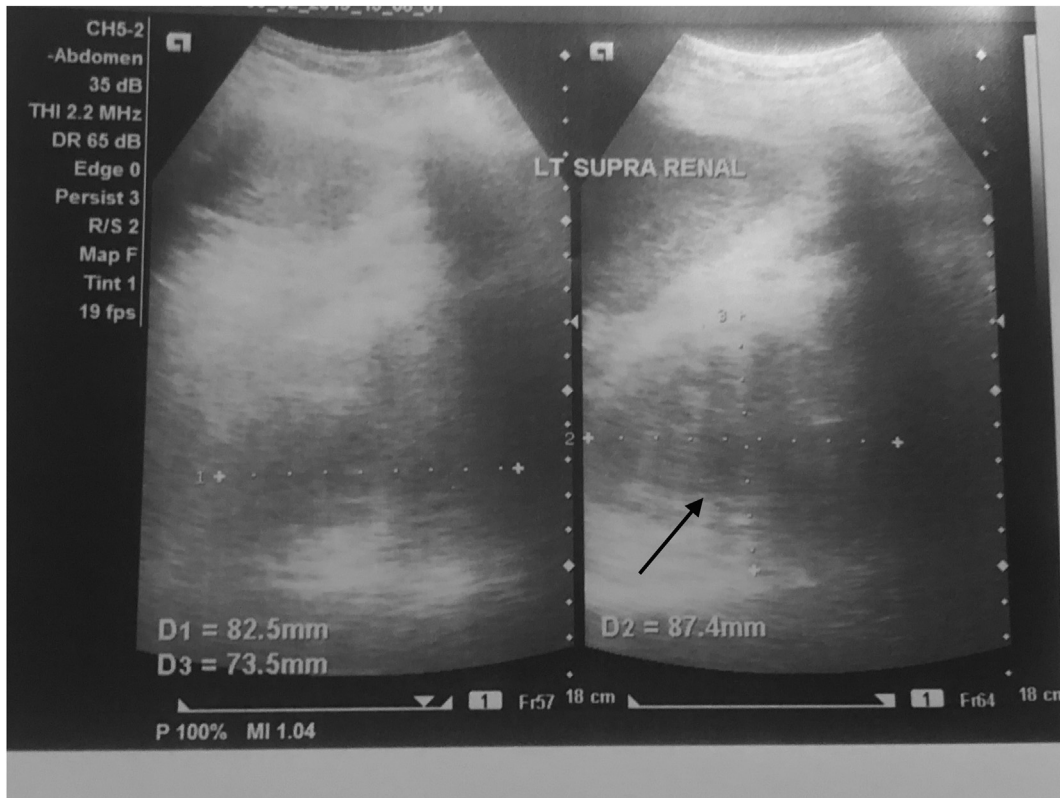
Abdominal ultrasound. Black arrow, showing an apparent mass on the upper pole of the left kidney/suprarenal measuring 83x87x74 millimetres.
